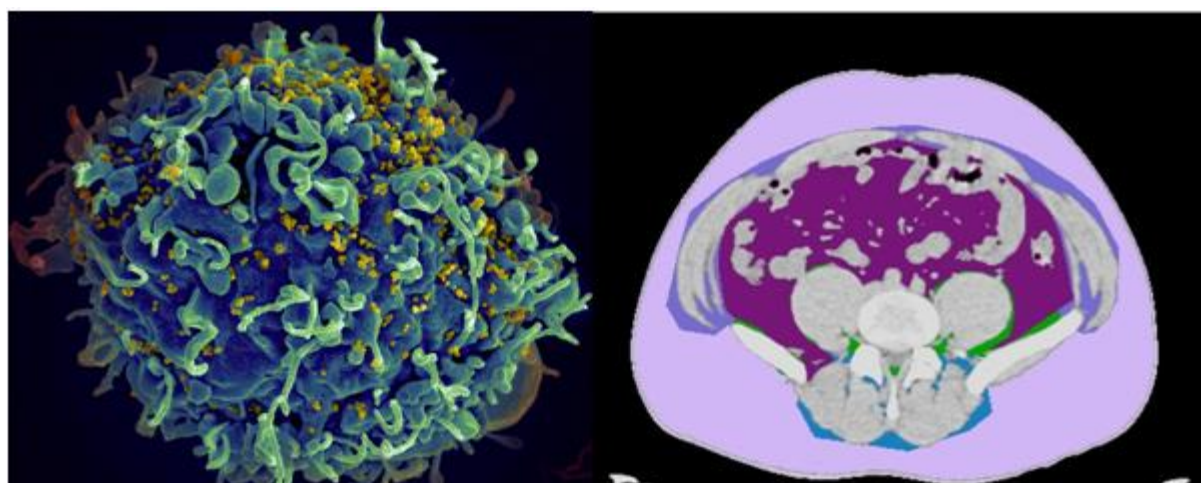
(Left) Human CD4+ T cell under attack by HIV. (Right) CT scan observing muscle quality over time after antiretroviral therapy (ART)
